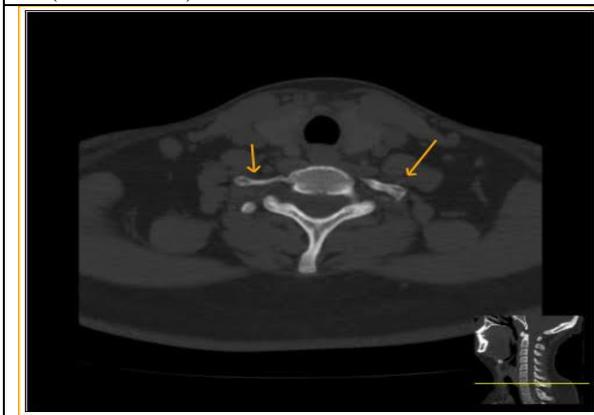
Axial CT cut at level C7 showing bilateral cervical rib(yellow arrow)
